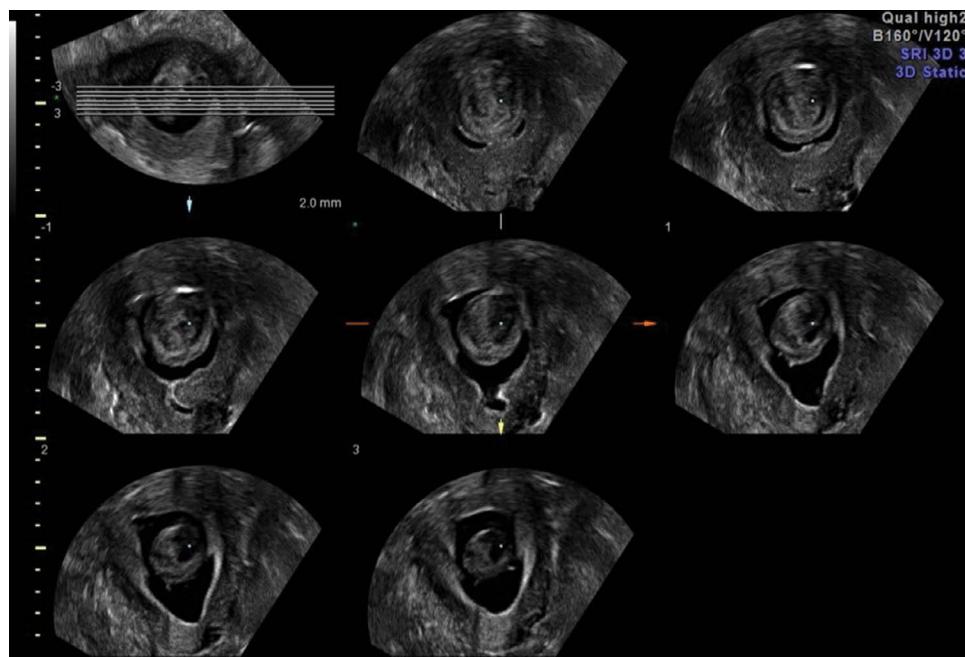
Saline sonogram of submucosal fibroid multiplanar view.
